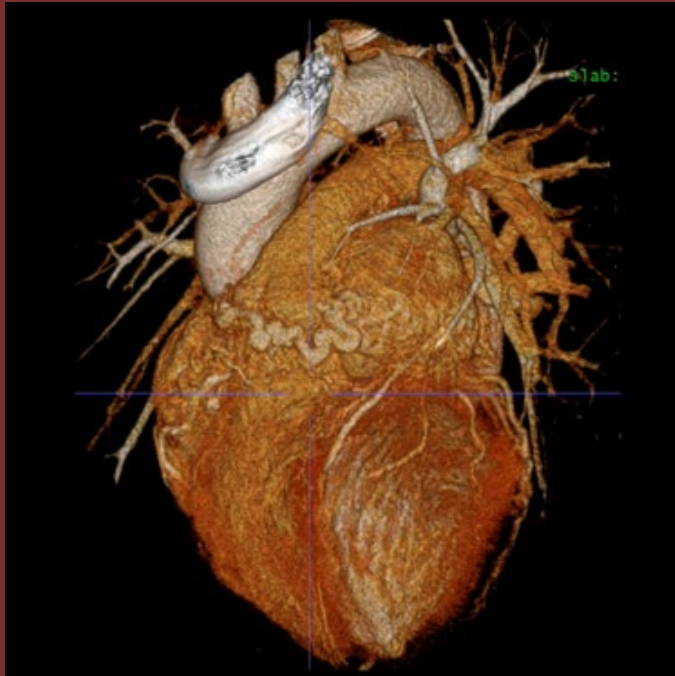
Cardiac CTA – Slab volume-rendering (A) and MPR (B) views at the level of the aorto-pulmonary groove
